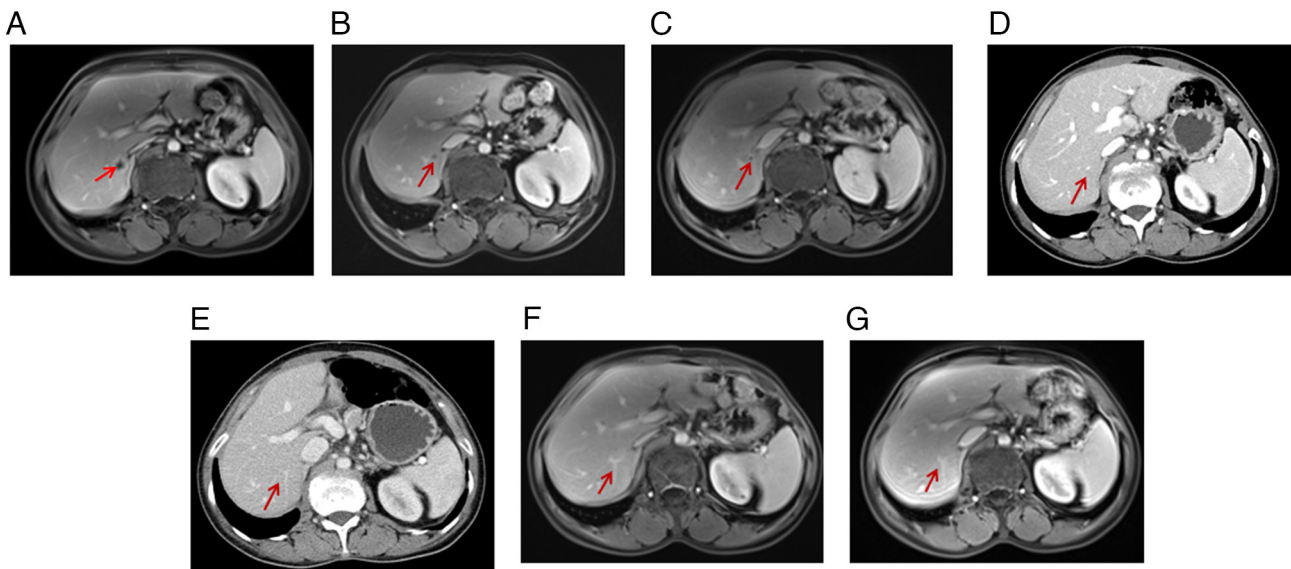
Abdominal MRI examination of the second lesion suggesting liver metastasis during treatment. (A) May 2021: During the routine enhanced MRI review of the abdomen, a new lesion suggesting liver metastasis (arrow) was discovered behind the original liver metastasis. (B) July 2021 and (C) September 2021: After treatment, enhanced MRI re-examinations showed that the lesion shrank gradually. (D) November 2021 and (E) February 2022: Enhanced CT re-examinations were performed, with no sign of the lesion. (F) July 2022: Enhanced MRI re-examination showed that the lesion was vaguely visible at this location. (G) November 2022: The previous lesion was not visible at all during the enhanced MRI examination. MRI, magnetic resonance imaging.
